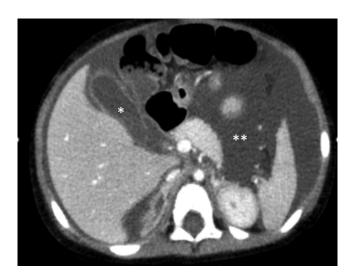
Abdominal CT image showing abdominal effusion (*) and an edematous wall of the gallbladder ().
